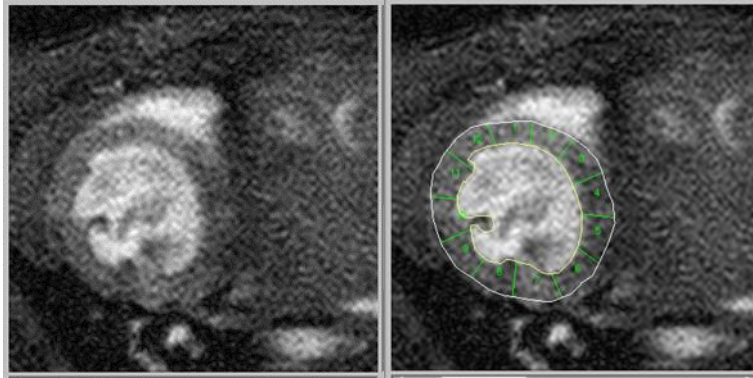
An example of a short axis cine MRI slice that has been optimised (left) and subsequently manually segmented (right).
